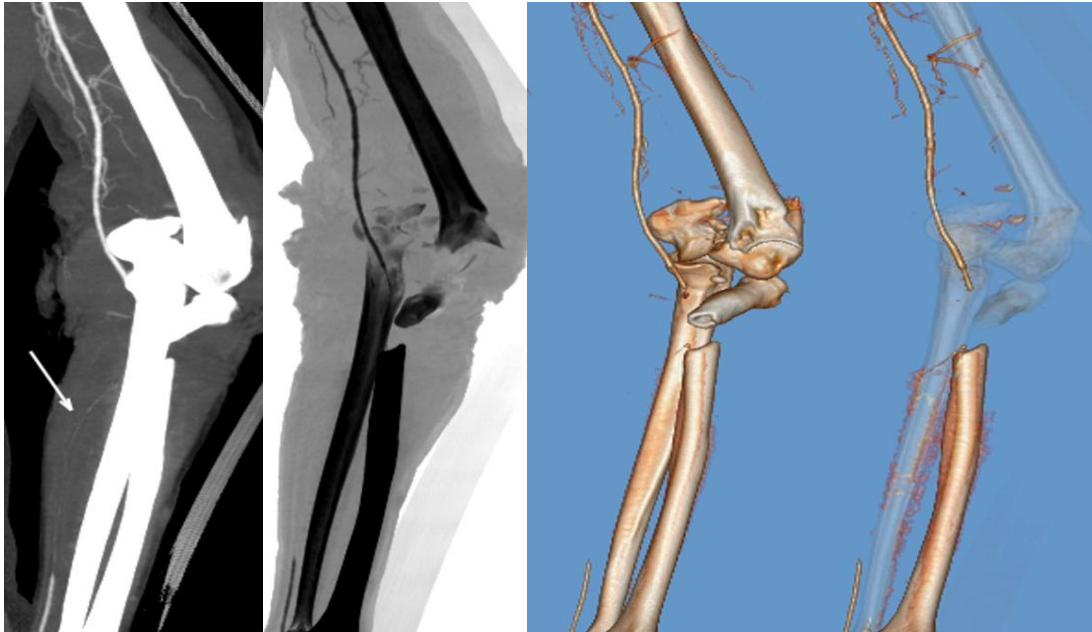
(A-D) CTA MPR (A), positive image (B) and 3D volume rendered (C,D) image reveal comminuted fracture lower end of left humerus with posterior dislocation, fracture proximal third of radius of forearm with displacement of fracture fragments, intramuscular hematoma of elbow & proximal forearm with occlusion of brachial artery bifurcation, radial artery & proximal two third of ulnar artery. Complete rupture & transection of brachial artery bifurcation was noted at surgery.
